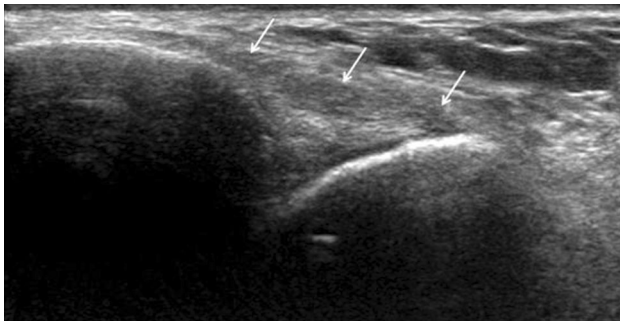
Anterior perimalleolar sonogram (oblique-external). The anterior fibulotalar ligament (*arrows*) appears as a thin echogenic band that extends from the anterior aspect of the lateral malleolus to the collum tali
